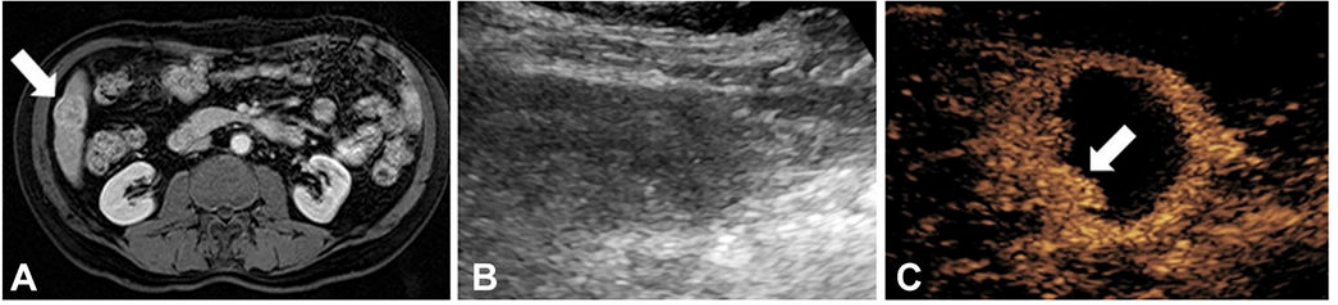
Treatment effect monitoring by contrast-enhanced ultrasound after trans-arterial chemoembolization (TACE) of hepatocellular carcinoma. (A) Post-contrast T1-weighted fat suppressed MRI demonstrating a $2.8 \times 2.6 \times 2.5$ cm segment VI LI-RADS 5 lesion (arrow) with arterial phase enhancement (and washout on delayed imaging) before TACE treatment. (B) Gray-scale ultrasound with difficulty delineating the lesion bed post-treatment. (C) Contrast-enhanced ultrasound of the same ultrasound window demonstrating the lesion with partial treatment response and some residual enhancement (arrow) concerning for viable tumor.
